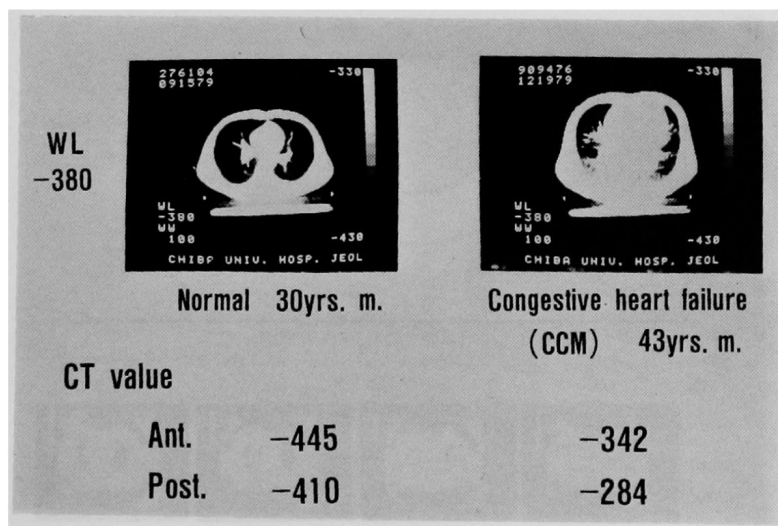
The pulmonary CT image and CT value at the fourth intercostal space in a normal subject and a patient with congestive heart failure of NYHA functional class IV. The CT image of the patient showed markedly dilated pulmonary vessels radiating from the hilus into the peripheral lung field with a dilated cardiac shadow. Abbreviations: WL=window level; CCM=congestive cardiomyopathy.
